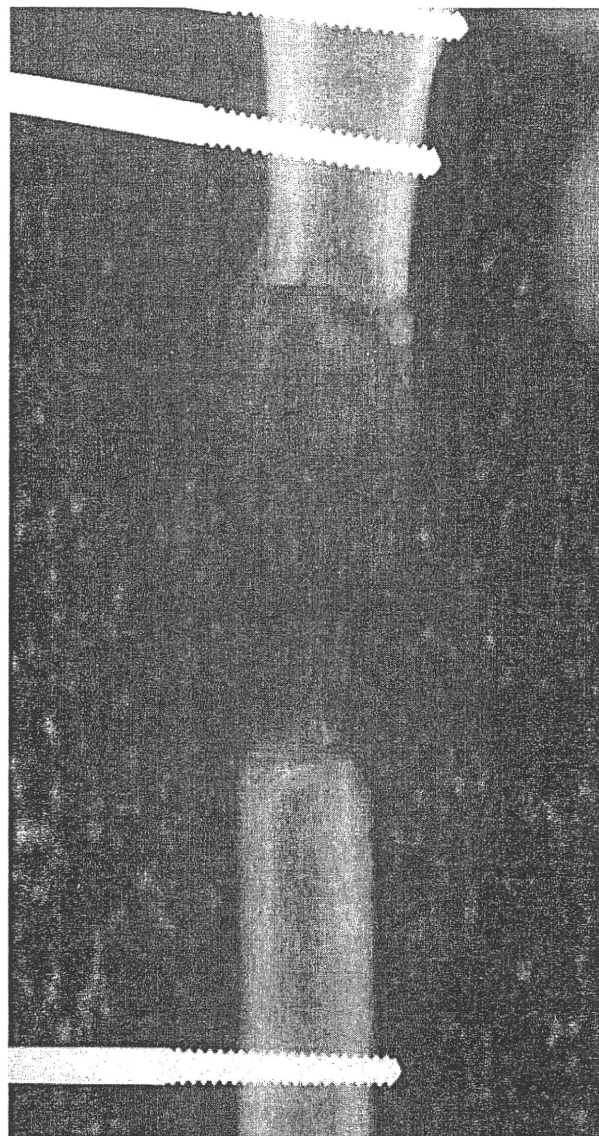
Anteroposterior radiograph of the right femur of a 19-year-old man with achondroplasia (case 5) just at the end of distraction demonstrating abundant fusiform-shaped callus formation.
